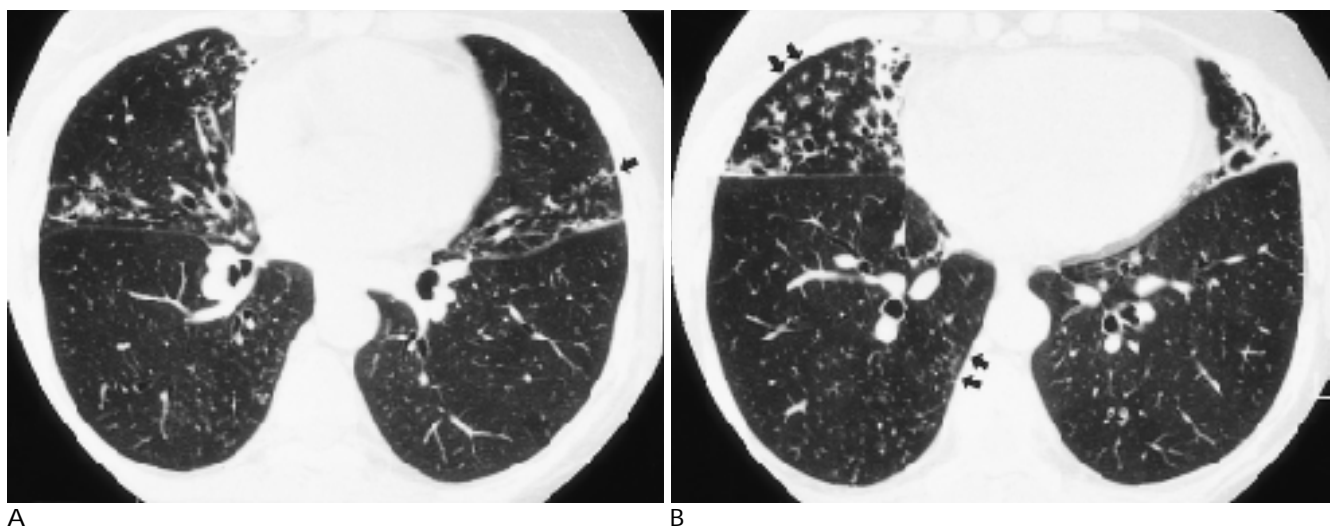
MOTT in a 55-year-old woman. HRCT scans at the level of inferior pulmonary vein (A) and ventricle (B) show bronchiectasis in the right middle lobe and lingular division. Also note the centrilobular nodules(arrows) in the right middle lobe, right lower lobe and lingular division.
